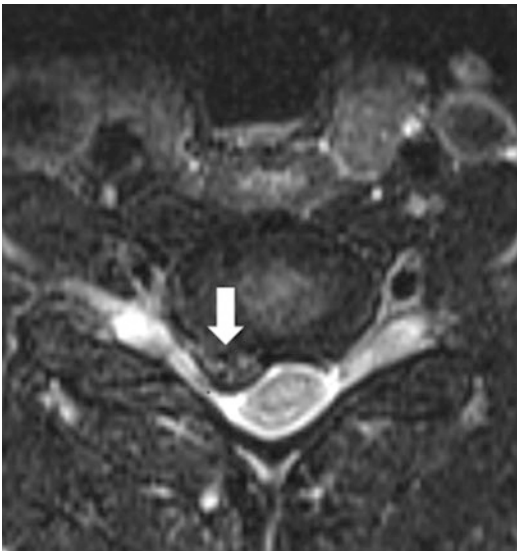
MRI demonstrating an acute herniated nucleus pulposus (*arrow*) causing nerve root compression. The increased T2 signal within the paracentral disc herniation suggests an acute process
